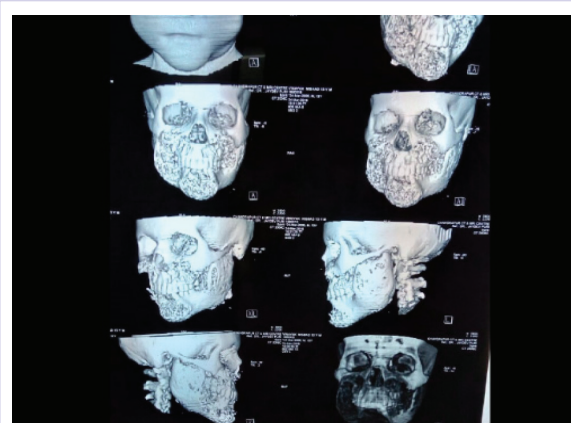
3D computed tomographic images showing osteolytic lesions in mandible and maxilla
